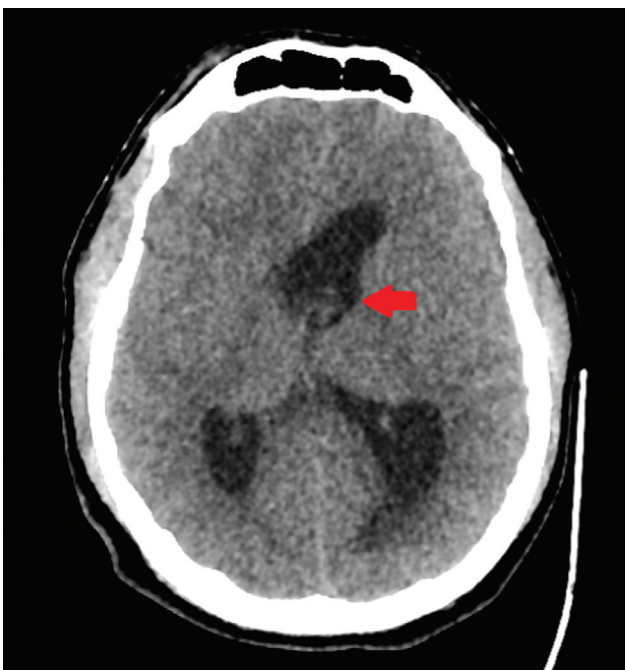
Preoperative head computed tomography in the axial plane showing acute hydrocephalus and a suspicious lesion at the level of the foramen of Monro in the left lateral ventricle (red arrow).
